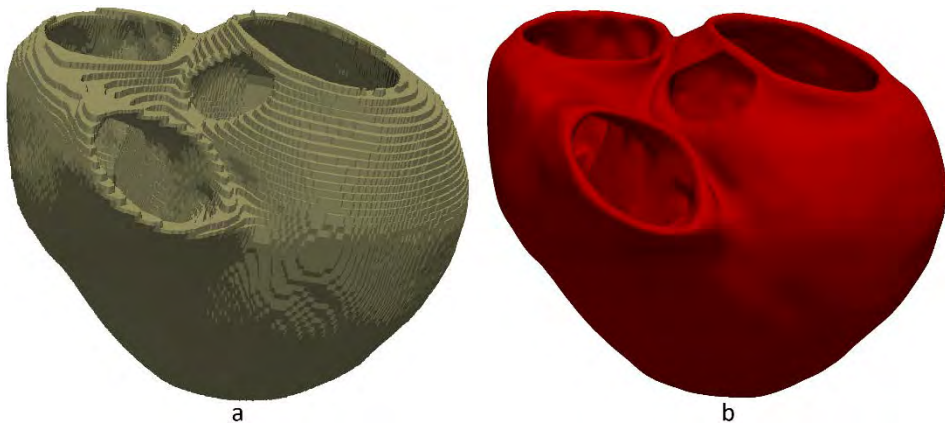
3D surface model of ventricles generated from DE-MRI segmentation. Antero-basal view of the 3D surface model, showing four holes corresponding to the four cardiac valves: mitral and aortic for LV, and tricuspid and pulmonary for RV. (a) Raw 3D isosurface as it was generated by Seg3D, showing a notable staircase effect. (b) Final version of the 3D surface model after global smoothing with ParaView and local refinement with Blender.
